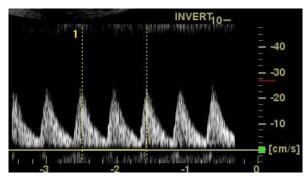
Two Heart Beat Reference (example in Doppler mode)
